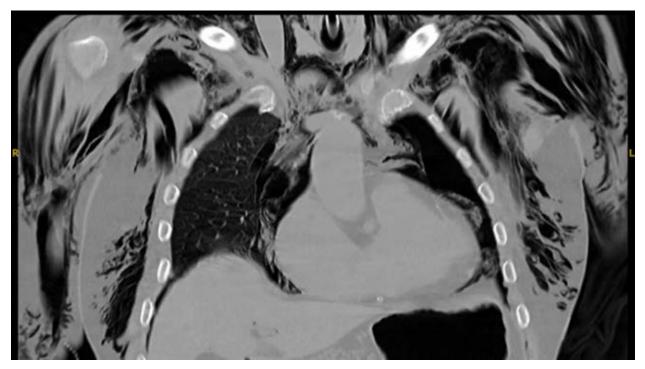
Computed tomography highlighting the massive subcutaneous emphysema and a residual anterior left pneumothorax.
